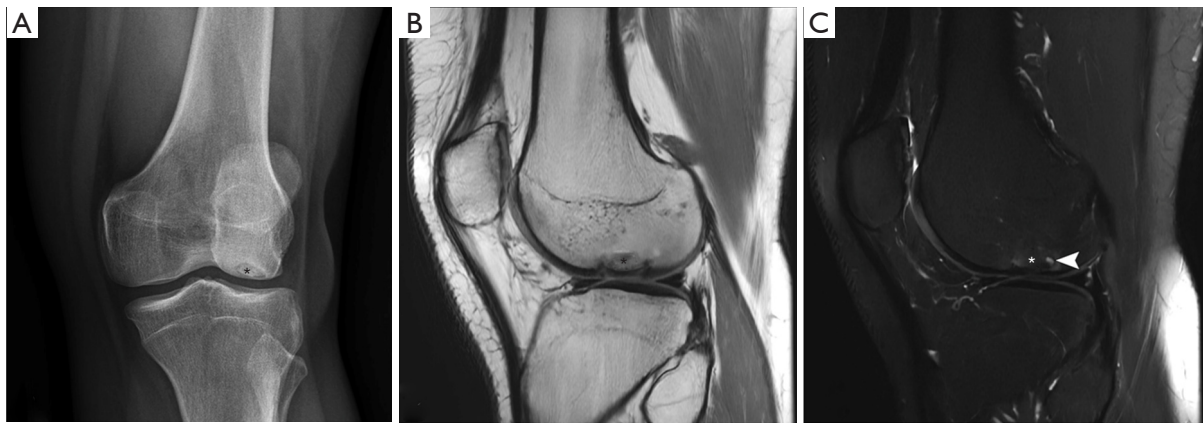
Osteochondral lesion imaging. (A) Frontal radiograph displaying previous osteochondral injury (asterisk) of the lateral femoral condyle. (B) Subsequent sagittal proton density MRI with osteochondral injury (asterisk). (C) T2 fat-suppressed MRI with osteochondral injury (asterisk) and subchondral cystic changes (arrowhead). MRI, magnetic resonance imaging.
